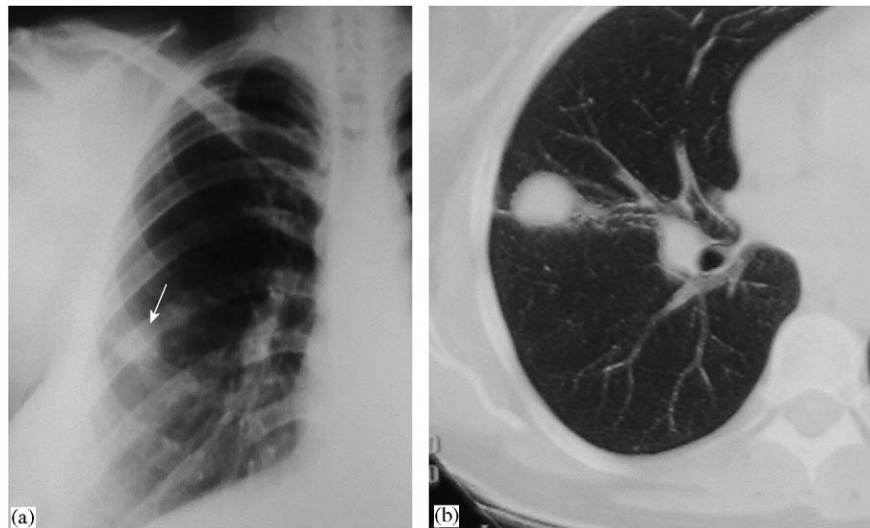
(a,b) Chest radiography and thorax tomography showing a mass with homogeneous density and well-defined margin, located major fissure.
